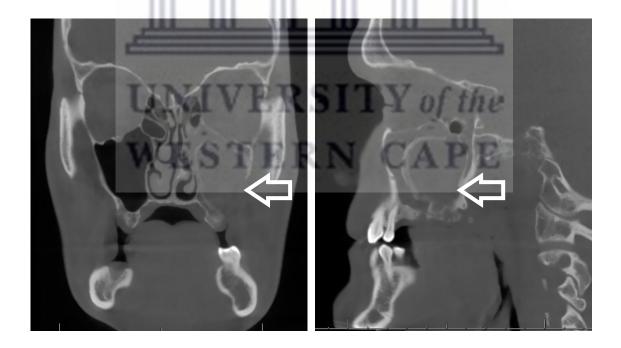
Post-operative coronal and sagittal CBCT showing recurrent residual cyst in left maxilla of the same patient in Figure 13.
